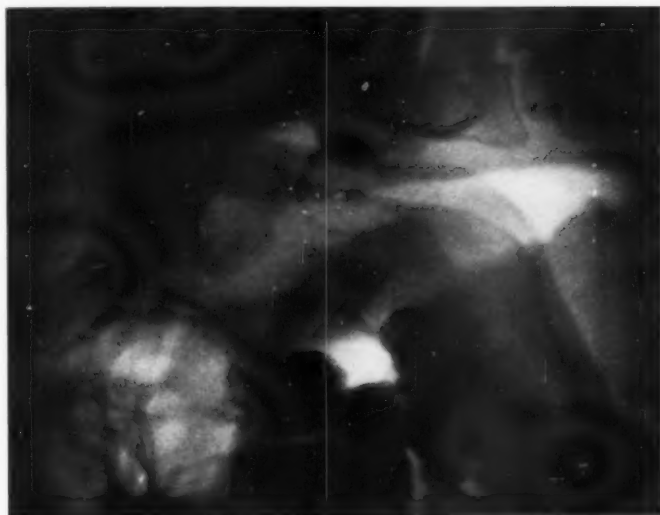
Same patient as on fig. 5. Roentgenogram a few hours after operation. Sitting position.
